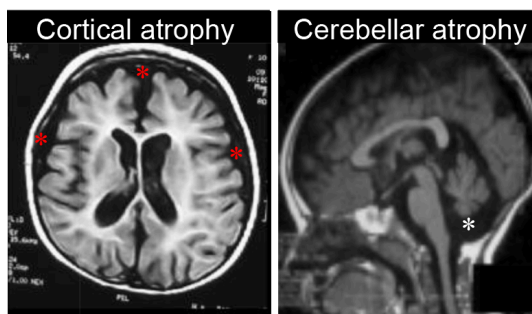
Examples of pediatric-onset neurodegenerative disorders according to brain MRI appearance.
